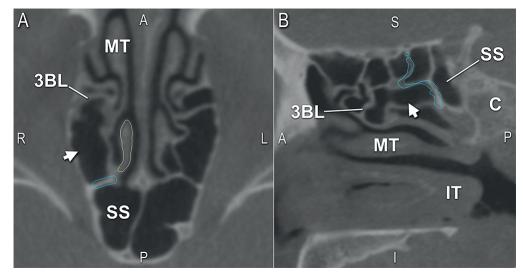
Fusion of walls within the posterior ethmoid. A) Axial CT image. B) Sagittal CT reconstruction. Yellow: superior turbinate, blue: basal lamella of the superior turbinate (4BL). The posterior ethmoidal region can be understood in most of the cases as one compartment (arrowhead) between the 3BL and the fused 4BL/ASW. IT: inferior turbinate, MT: middle turbinate, SS: sphenoid sinus. A: anterior, I: inferior, L: left, P: posterior, R: right, S: superior.
